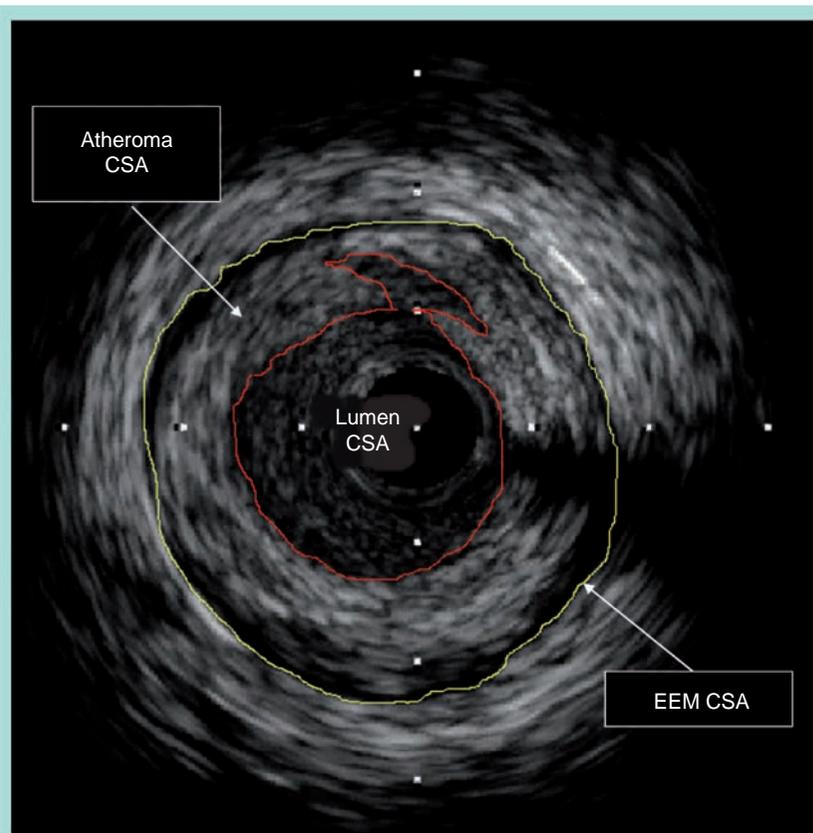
Basic intravascular ultrasound measurements of a coronary artery with atherosclerotic disease.
